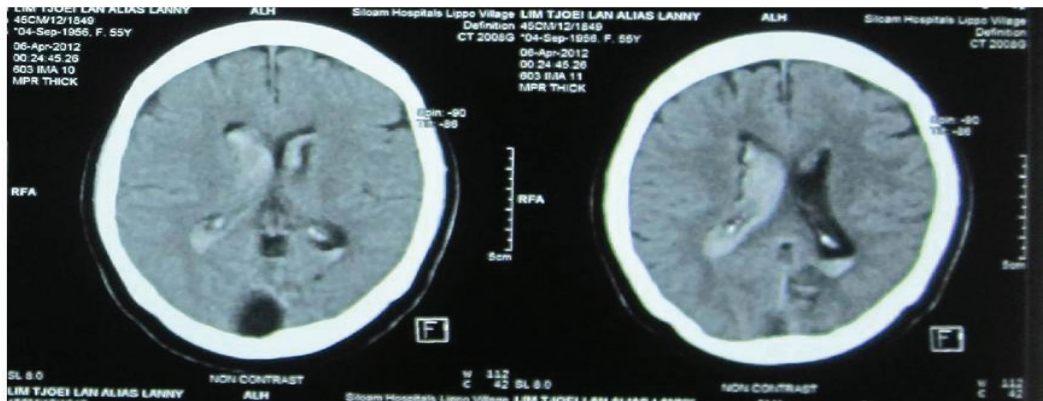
Preoperative-axial Head CT-scan Showing an Intraventricular Hemorrhage on Both Side
